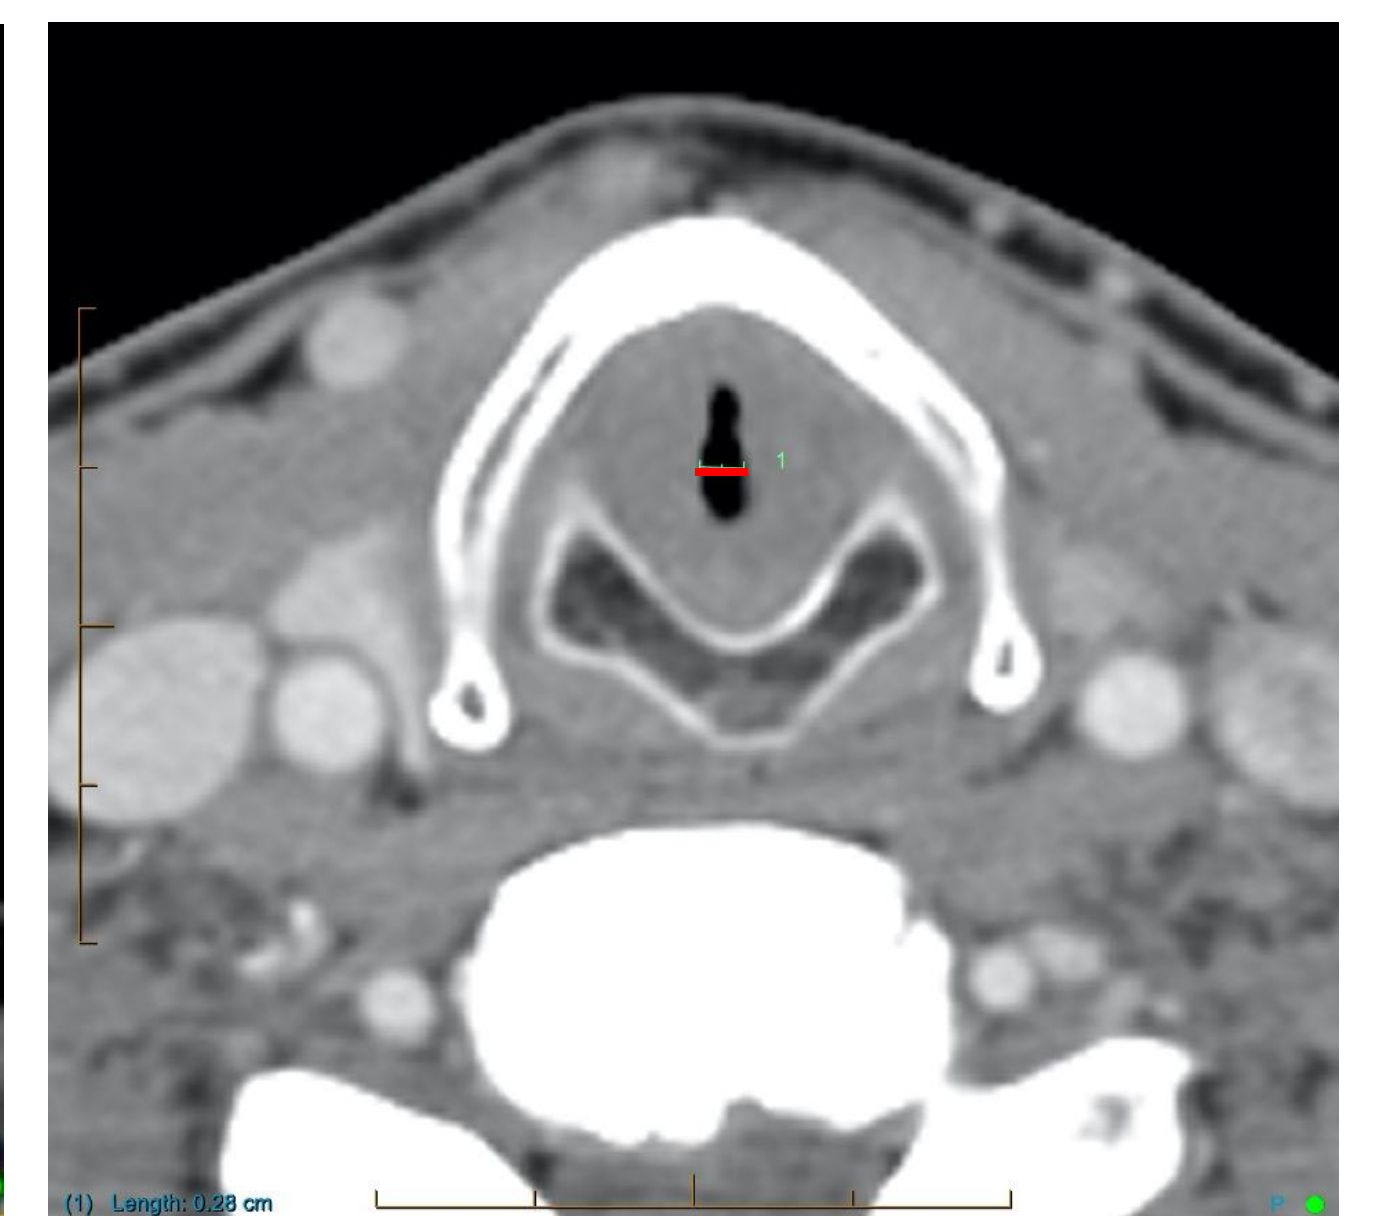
CT scan with contrast in the axial plane demonstrating severe subglottic narrowing to 3mm (red measurement).
